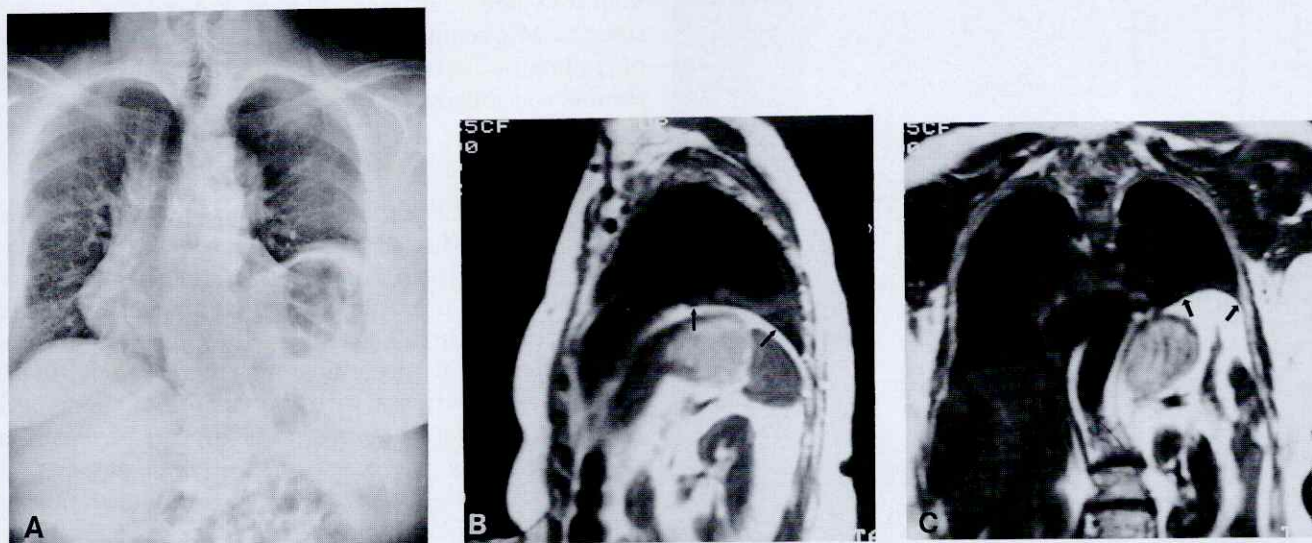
Magnetic resonance images excluding diaphragmatic injury: (A) Admission chest x-ray film in a 65-year-old woman revealed focal elevation of the apparent left hemidiaphragm and mediastinal shift to the right. Sagittal (B) and coronal (C) MR images, T₁-weighted, show an intact low-signal left hemidiaphragm (arrows) and left basal atelectasis excluding rupture of the left hemidiaphragm.
